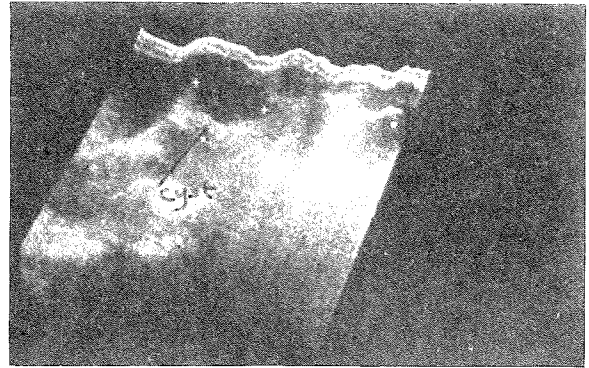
Second ultrasound showing cyst decreased in size. (post-drainage).
